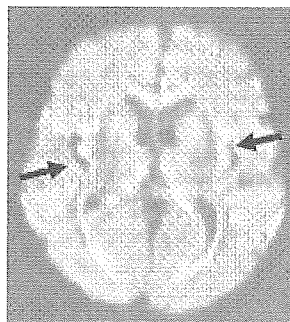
Creutzfeldt-Jakob病(MRI 拡散強調画像)
